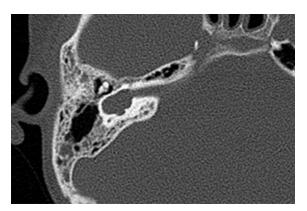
The CT of right temporal bone revealed the replacement of a normal cochlea and vestibule with lobulated cavity.
